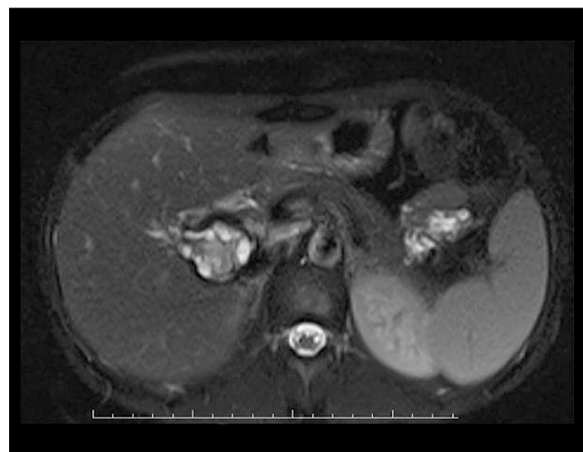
MR imaging shows a heterogeneous hyperintense lesion at the level of the portal hilus in the liver on axial T2 fat-suppressed sequences.
